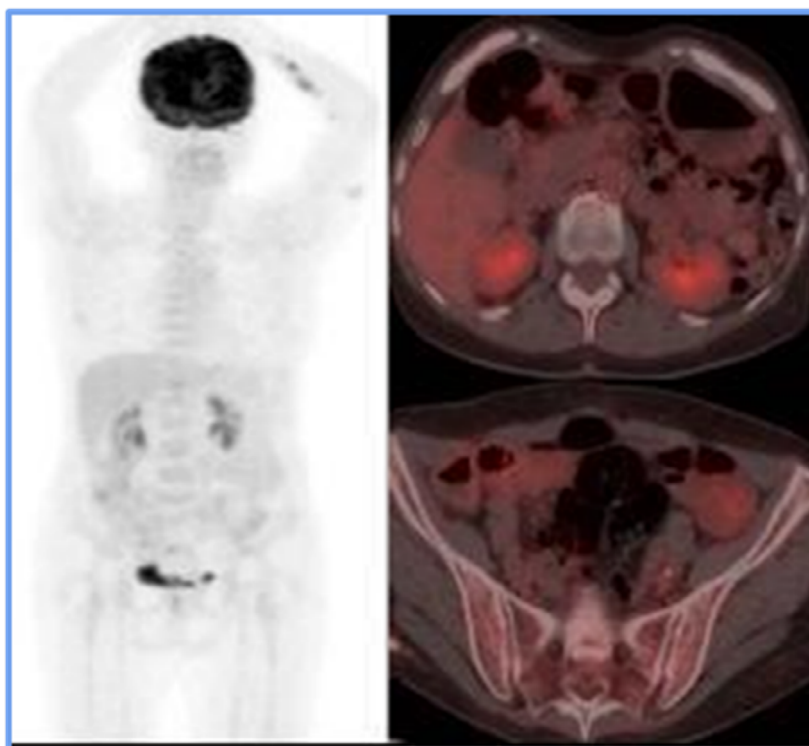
PET CT scan following the rescue scheme. It presents the resolution of adenopathy in the proper internal iliac chain, which is related to morphological and metabolic responses to medical treatment.
